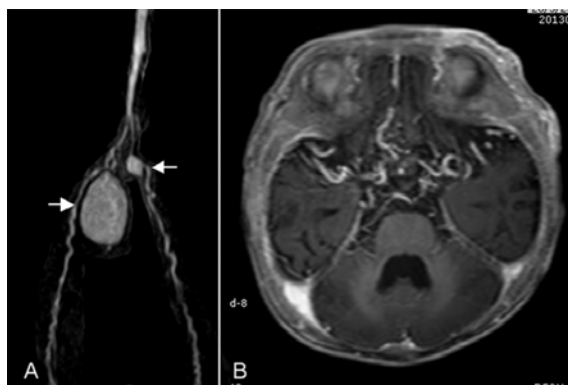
(A) Contrast Enhanced Magnetic Resonance Angiography (CE-MRA) of infra-renal abdominal aorta revealed two abnormal outpunching lesions which are a larger right internal iliac arterial aneurysm and a smaller left common iliac arterial aneurysm, (B) Contrast Magnetic Resonance Imaging (MRI) showed abnormal morphological change with tortuosity and dilatation of the circle of Willis.
